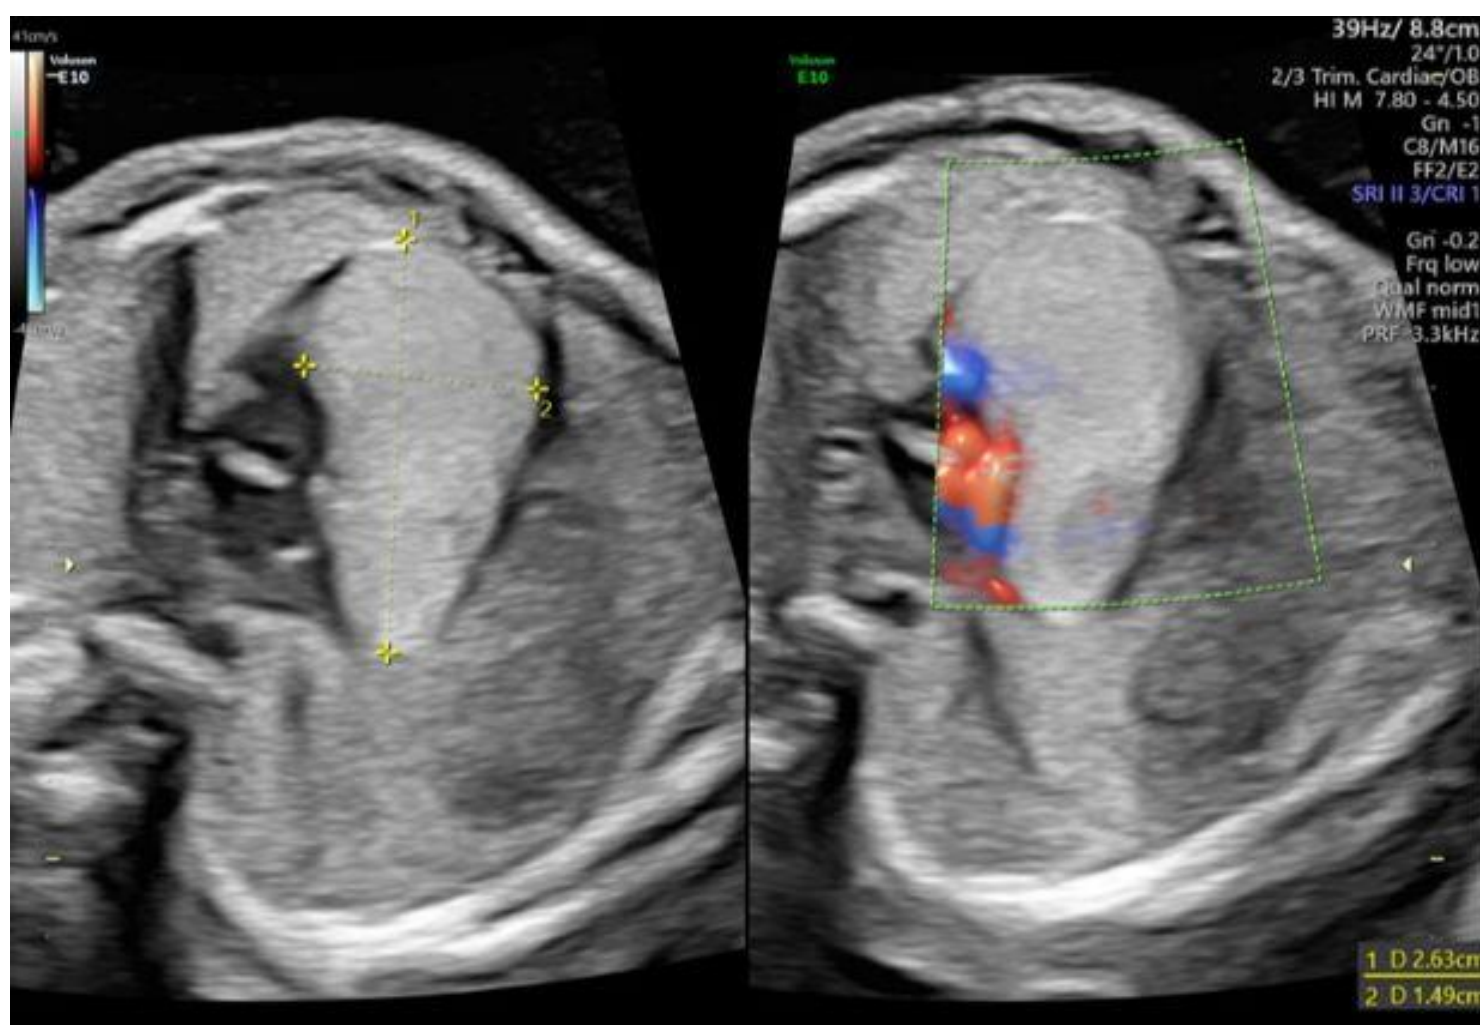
Echocardiographic examination showed a hyperechogenic homogeneous area of 26x15 mm at the atrio-ventricular junction
